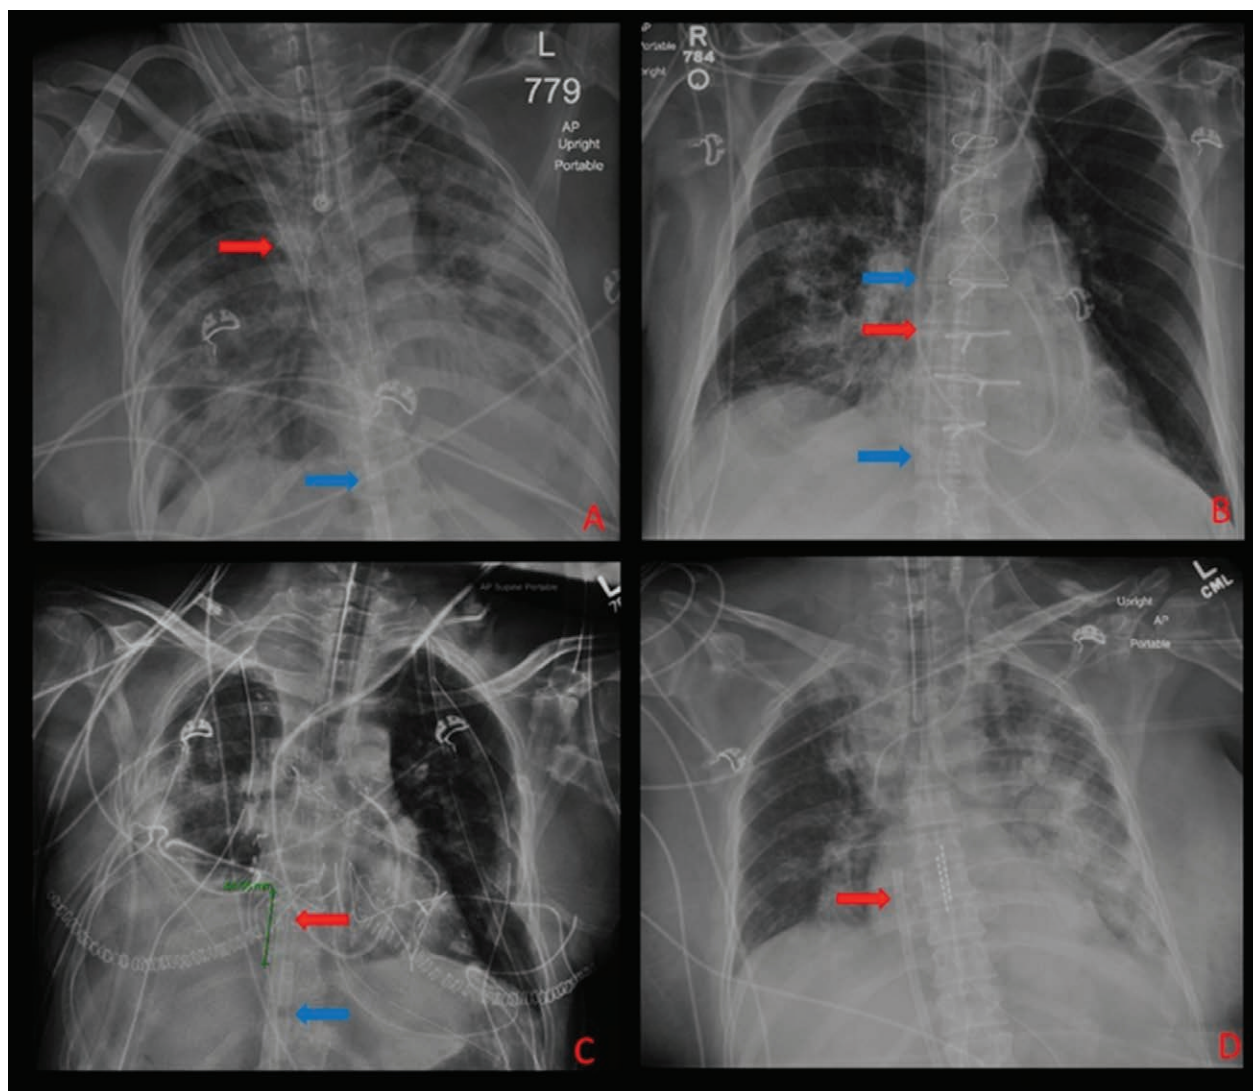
Chest x-rays of patients with common venovenous extracorporeal membrane oxygenation cannulation strategies. *Red arrows* represent return sites of oxygenated blood to the patient. *Blue arrows* represent drainage of venous blood from the patient. (A) Femoral–right internal jugular cannulation. (B) Dual-lumen right internal jugular cannulation with Avalon Elite cannula. (C) Femoral–femoral cannulation with return cannula at the junction of the inferior vena cava (IVC) and right atrium and drainage in the IVC. (D) Femoral–femoral cannulation with the return cannula in the right atrium. The drainage cannula (not pictured) is in the femoral vein or distal IVC.
